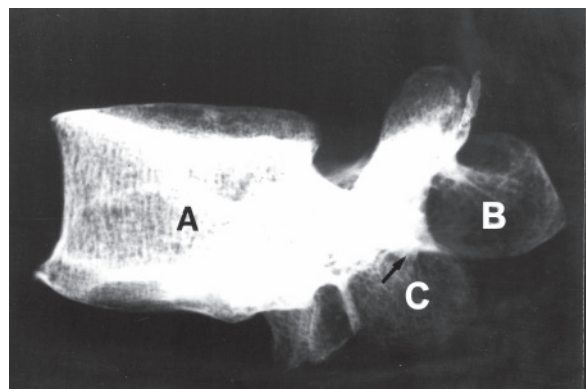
Radiograph of lumbar vertebra showing: A — body of the vertebra; B — spine; C — rudimentary inferior articular process on the left side marked with arrow.
